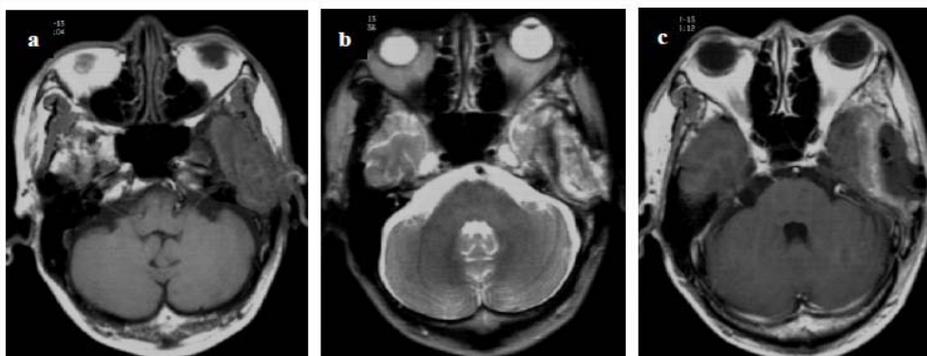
MRI plane and enhancement scans. TIWI scan (a) shows an oval bump shadow in the left tempus, with the center main body showing an uneven slightly low signal and an equisignal edge. T2WI (b) shows an uneven high signal in central lesions, and the signal of the edge is slightly low. T1WI enhancement (c) shows the central lesions mostly without enhancement, and the edge is irregular and obviously unevenly enhanced.
